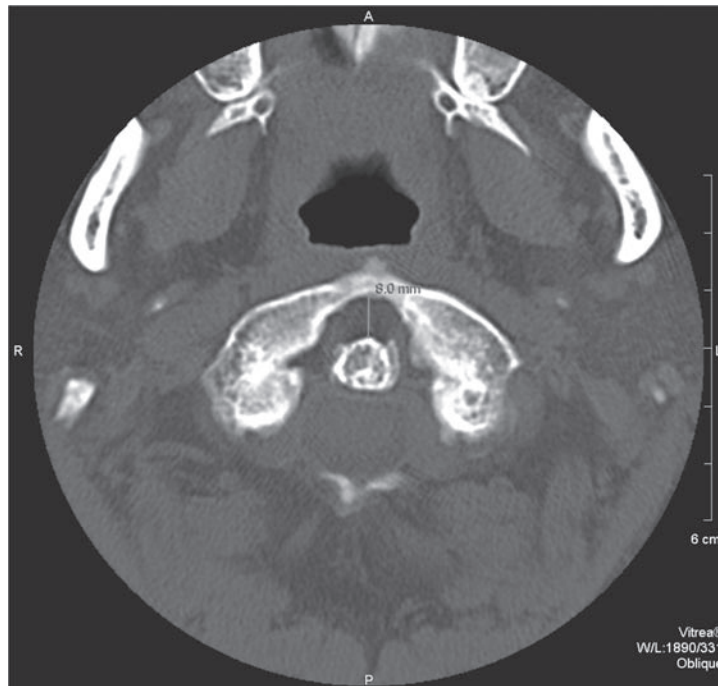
Transaxial CT in bone window showing an increase in atlanto-axial interval (8.0 mm). No associated bony fracture is seen.
